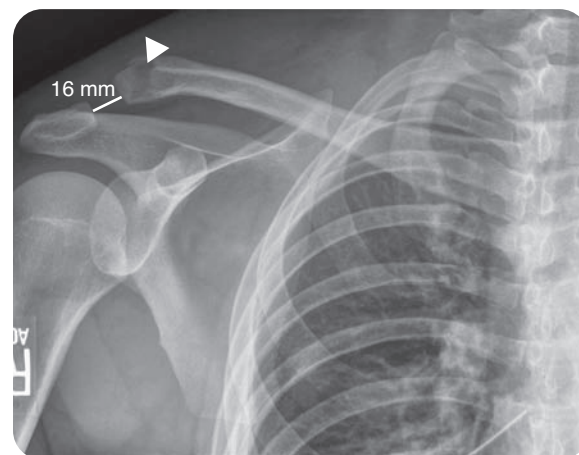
An anteroposterior radiograph of the right shoulder in a 30-year-old patient who was involved in a motorcycle collision, demonstrating an acute fracture through the distal third clavicle (arrow) and widening of the acromioclavicular joint by 16 mm.
